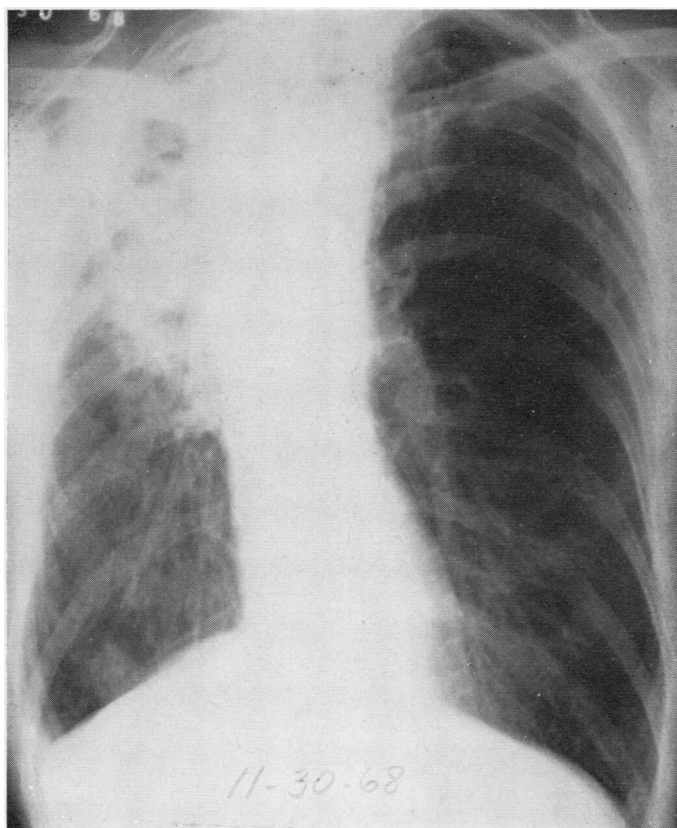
Chest radiograph of the same patient as in Fig. 2 (30/11/68) reveals marked progression with cavitation.
